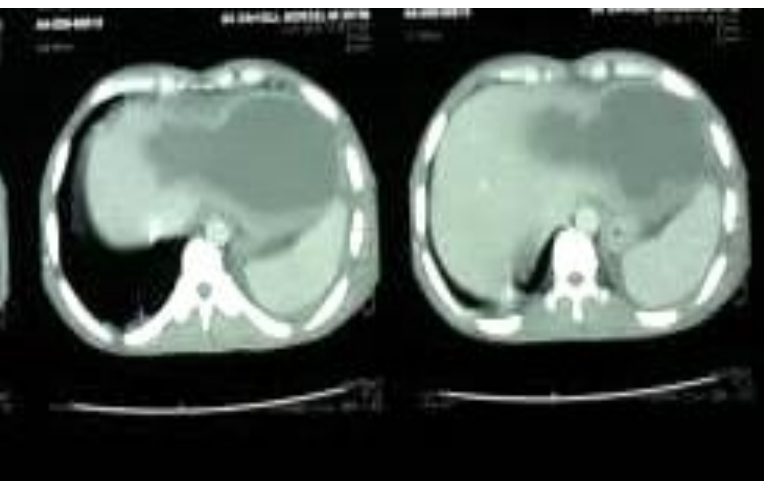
Initial abdominal Computed Tomography (CT) scan showing Left Lobe liver Abscess 12*9 cm in the left lobe with left sided reactive pleural effusion.
